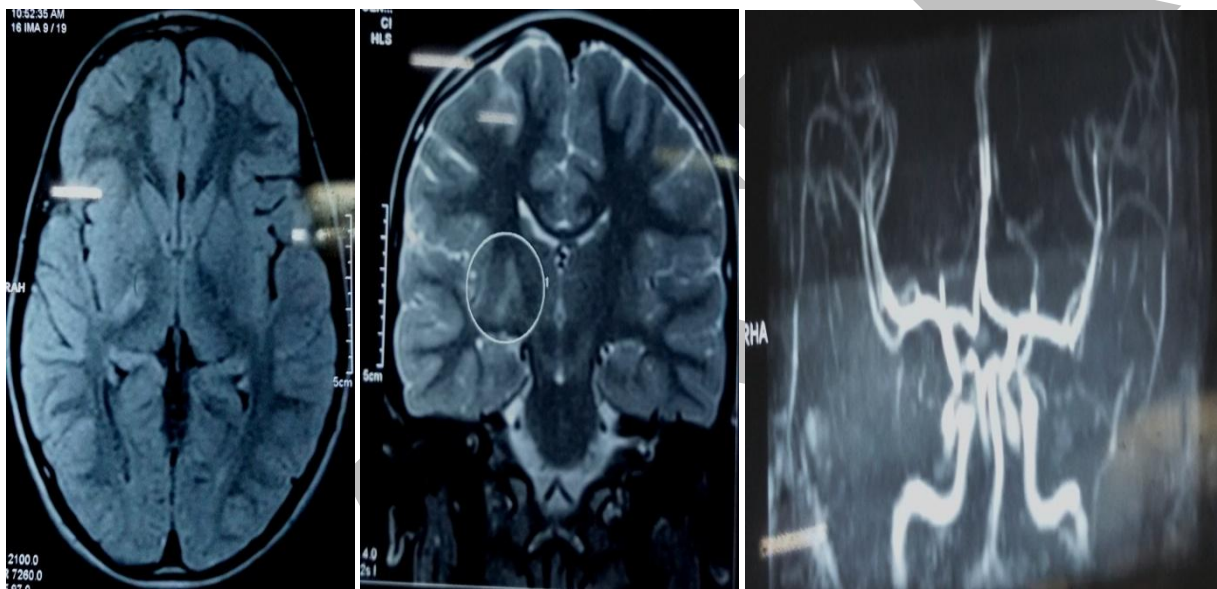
MRI brain revealing hyperintense lesion in internal capsule and normal angiogram. There was no diffusion restriction or contrast enhancement.
